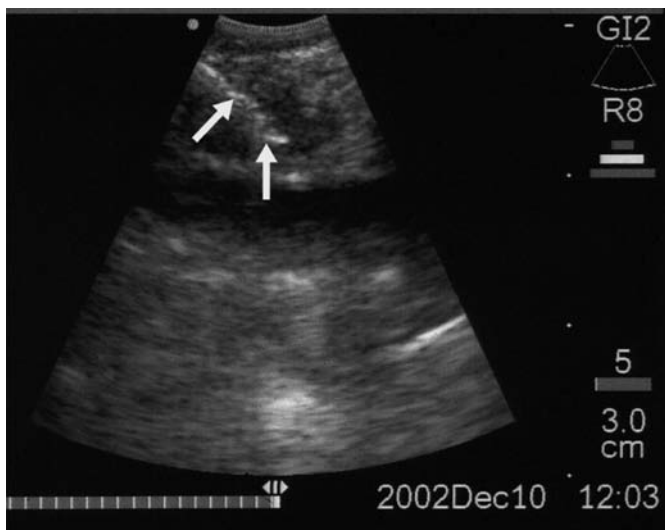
EBUS-TBNA in position 4 left in the animation. In the ultrasound image the needle is visible in the lymph node.
